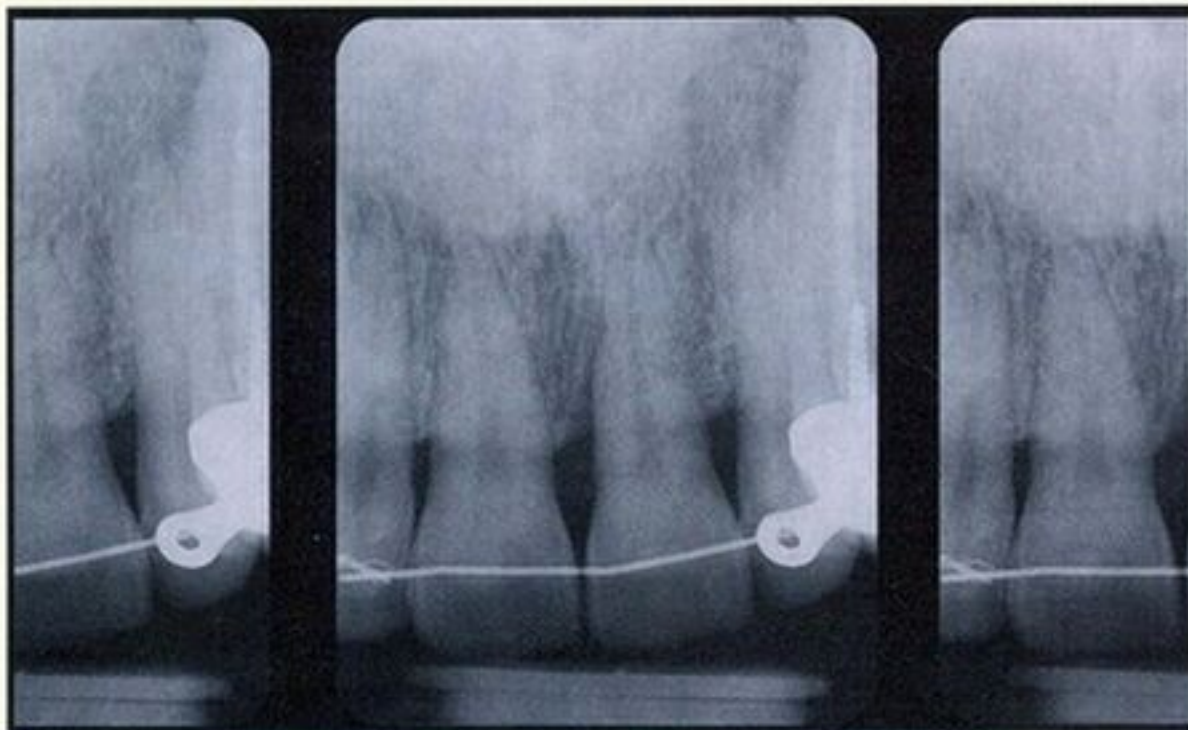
Posttreatment close-up radiograph of the maxillary central incisor region. Note evidence of bone fill with residual vertical, but solid, bone profile.
